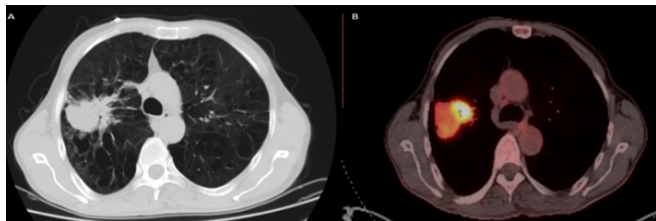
(a) Thoracic CT image of a lesion in the right upper lobe, (b) PET/CT image of the lesion in the right upper lobe, showing increased FDG uptake.
